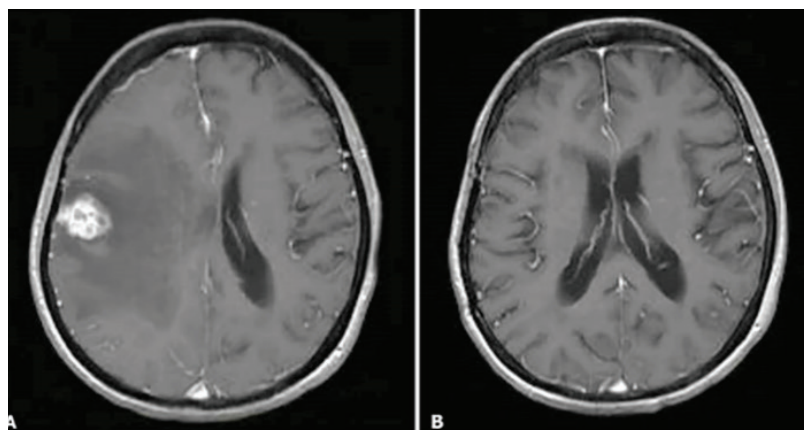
Axial section T1-weighted image with gadolinium contrast on magnetic resonance imaging (MRI). (A) Preoperative; (B) Evaluation after anti-tuberculosis treatment for 18 months was completed.
